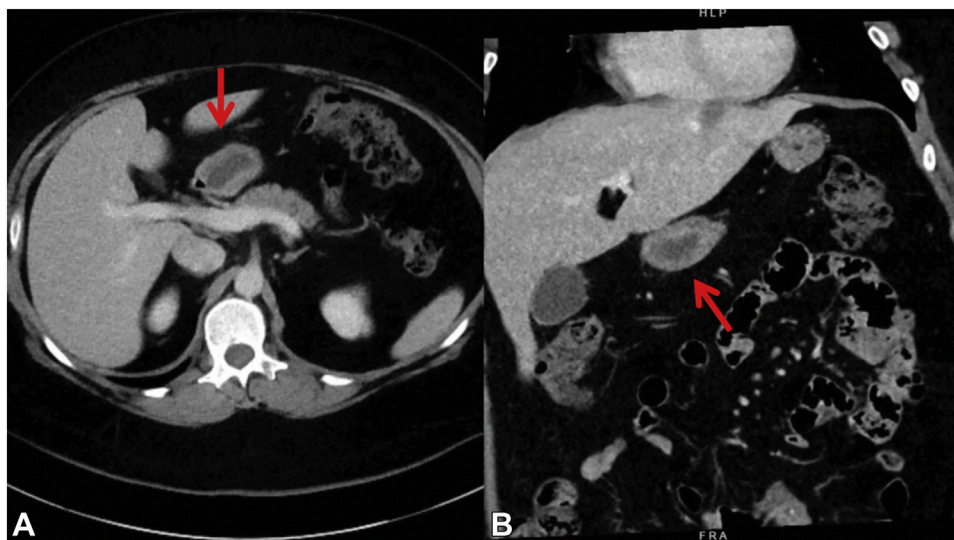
Sagittal (A) and coronal (B) sections of the abdominal CT scan with contrast demonstrating the cystic lesion (arrows) with diameters of $3.2 \times 1.2 \times 1.1$ cm in close proximity to the pancreatic body but without any pancreatic abnormalities.
